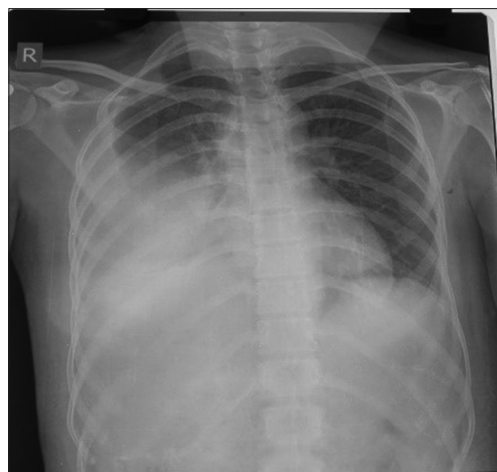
Postoperative X-ray of the patient showing moderate effusion
